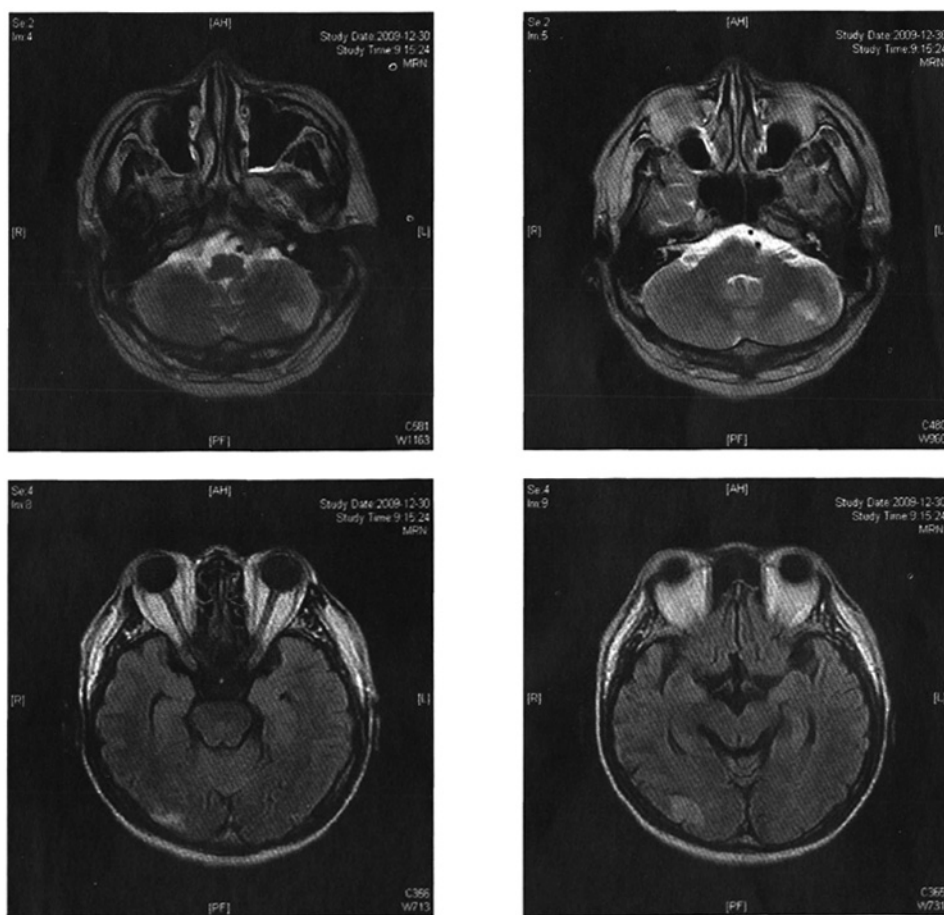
Head magnetic resonance imaging shows acute infarction of left cerebellum and right occipital lobe
